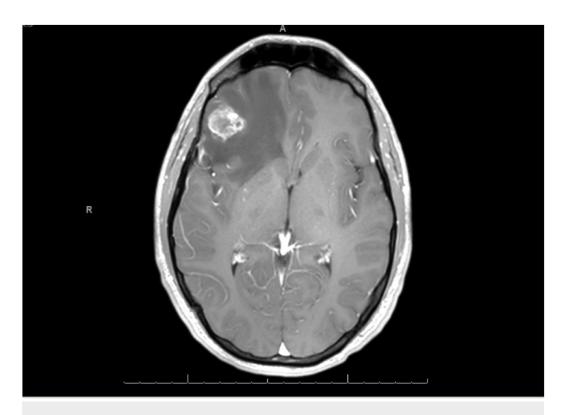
Initial Brain MRI
